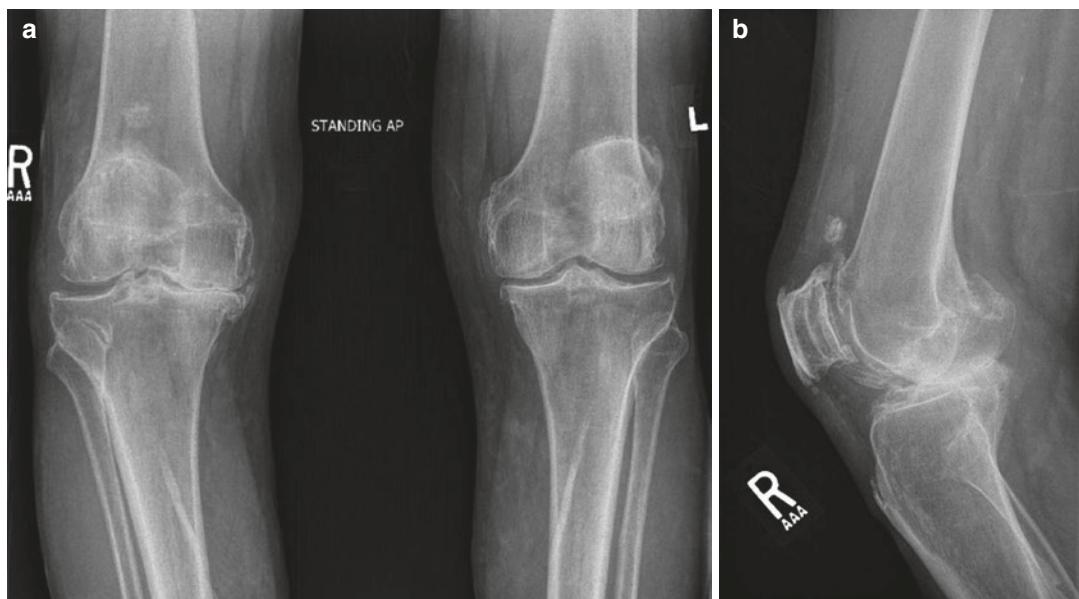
Preoperative weight-bearing anteroposterior (a) and lateral (b) radiographs demonstrating advanced tricompartmental osteoarthritis with varus deformity and posterior and suprapatellar osteophytes
